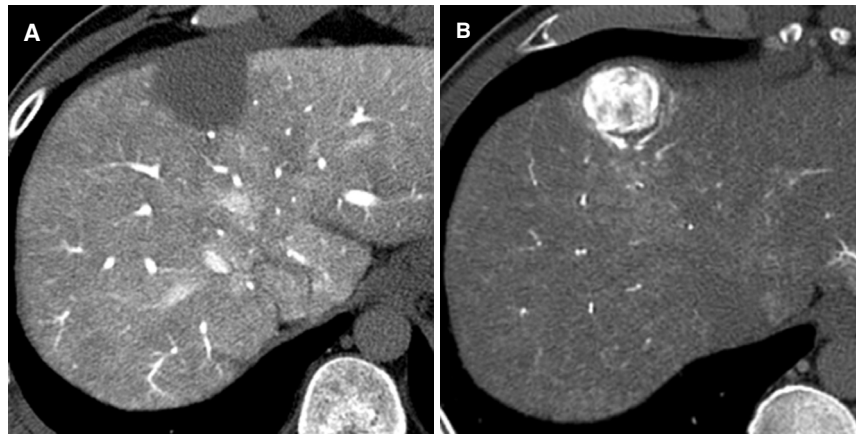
Example of advanced (moderately differentiated) hepatocellular carcinoma in cirrhotic liver. A: on CT during arterial portography, there are hypodense nodule compared to background liver, which represent loss of nodular portal flow; B: on CT during hepatic arteriography, the lesion shows marked hyperdensity compared to the background liver, which indicate increased nodular arterial flow. This hypervascular pattern indicates definite malignant nodule such as moderately differentiated hepatocellular carcinoma
